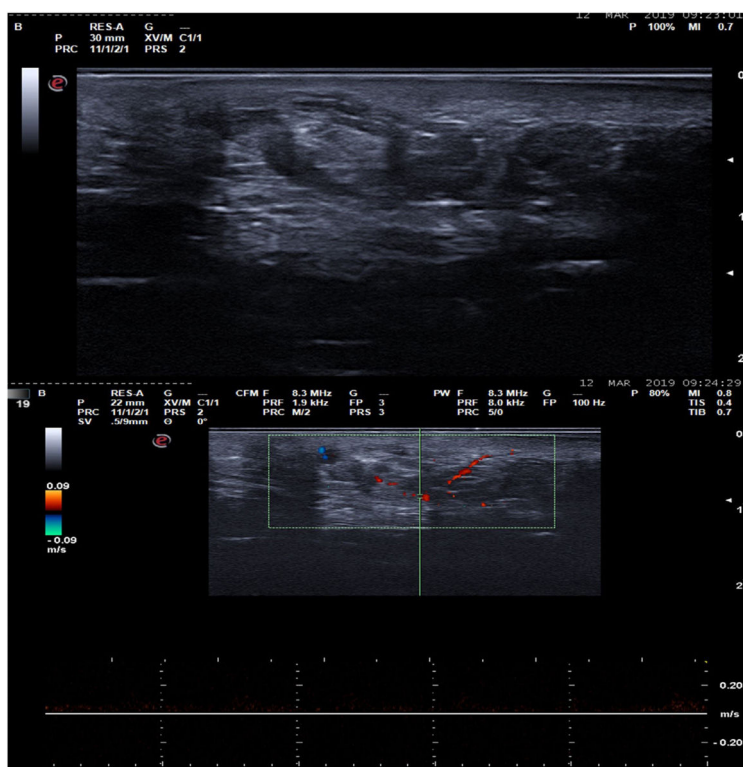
A, B-mode ultrasound image showing a poorly delimited, largely hypoechoic lesion containing tubular hypoechoic structures and scattered hyperechoic areas. B, Spectral Doppler ultrasound image, showing focal intralesional hypervascularization corresponding to high-flow, low-resistance vessels.
